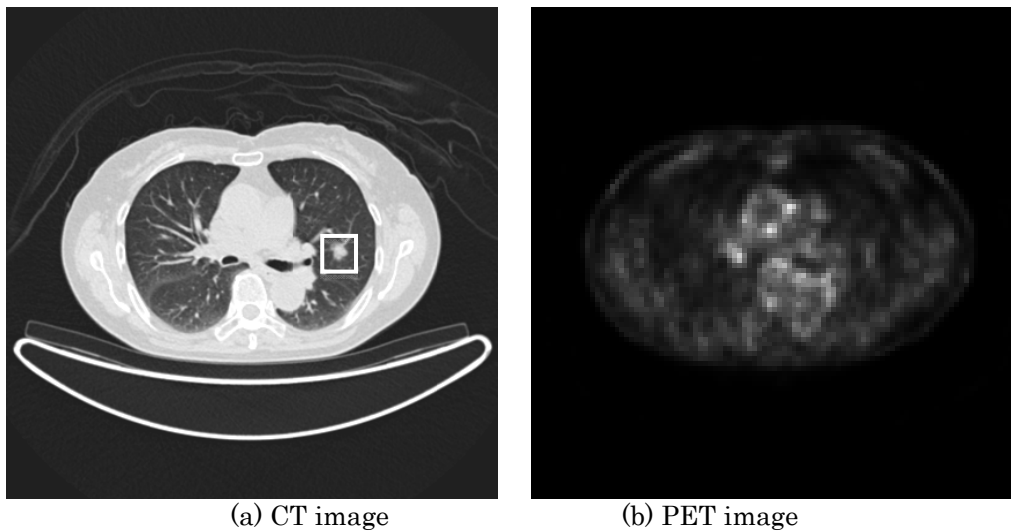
Nodule detected by CT image. Box indicates the nodules detected by the proposed method. PET image does not have high metabolic information. However, CT image has 1.3-cm nodule in left upper lobe; proposed method detected the nodule using CT image.
